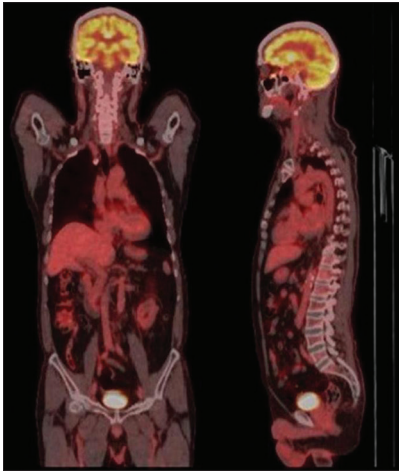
PET scan: Physiological FDG distribution in the brain, mediastinum, heart, liver, kidneys, and urinary bladder. No obvious abnormal FDG uptake in the internal organs
